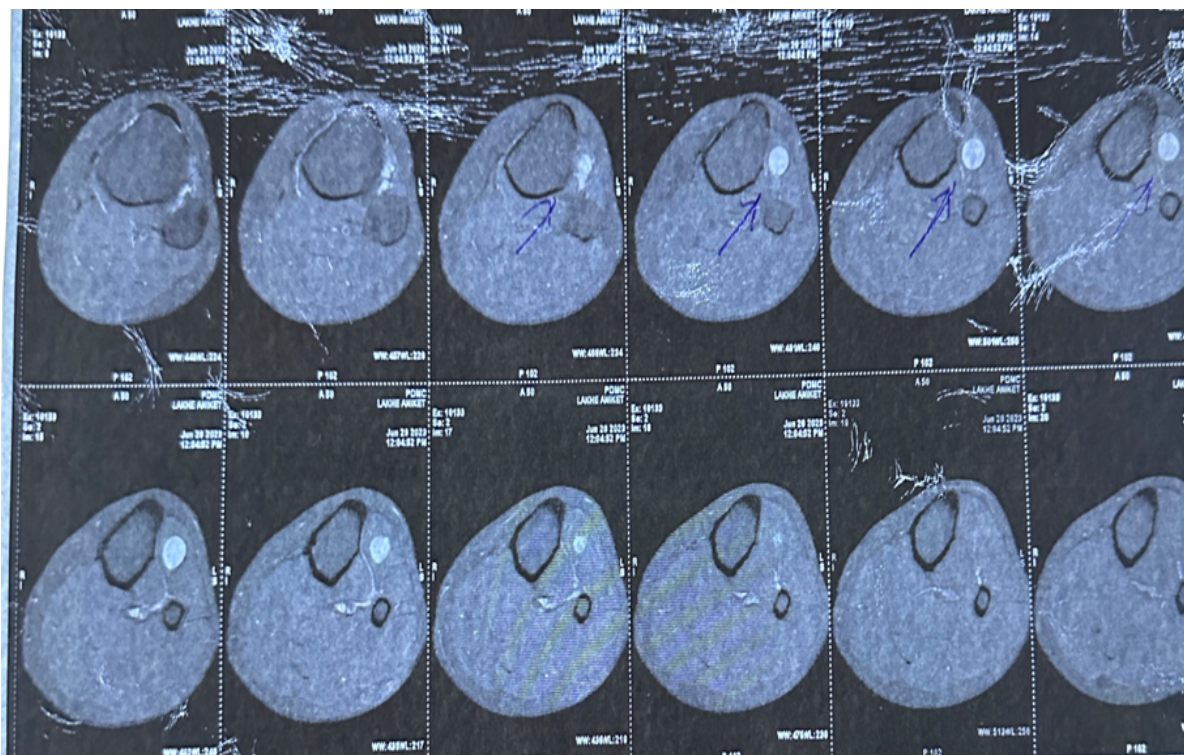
MRI left knee -Axial sections
